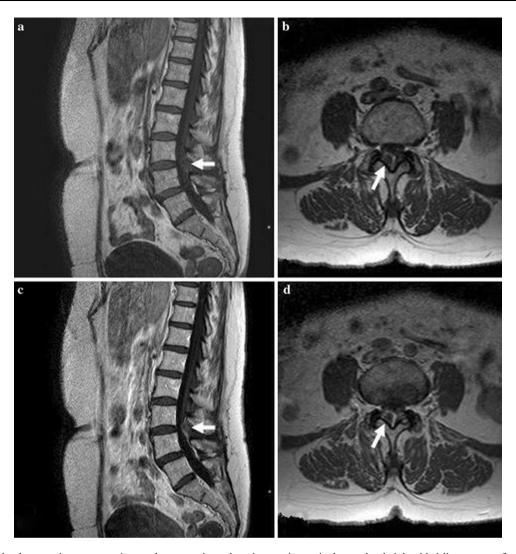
T1-weighted magnetic resonance image demonstrating a hypointense intraspinal extradural right-sided ligamentum flavum cyst (white arrow): a sagittal pre-gadolinium, b axial pre-gadolinium, c sagittal post-gadolinium, d axial post-gadolinium
